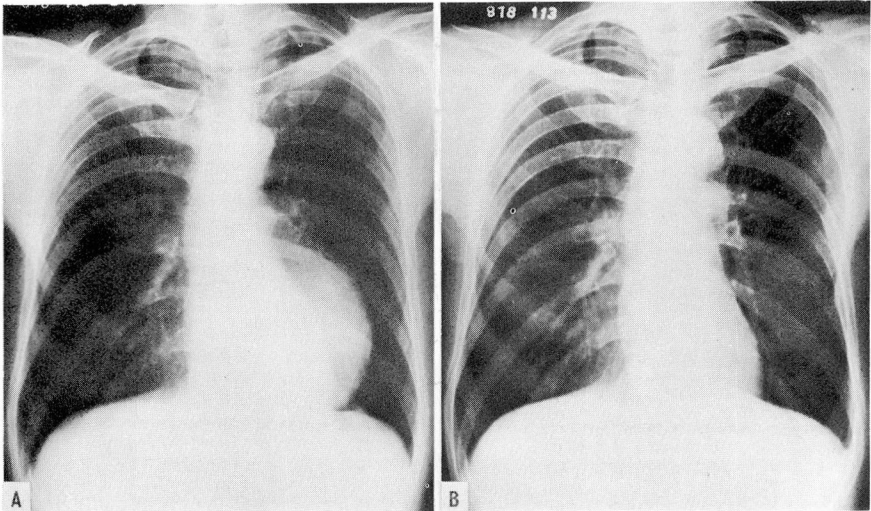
A, Preoperative, and B, postoperative roentgenograms of the only definitely syphilitic aneurysm in the reported series of patients. Syphilitic aneurysms do occur distally to the aortic arch. Radicular back pain was this patient's only significant symptom.
